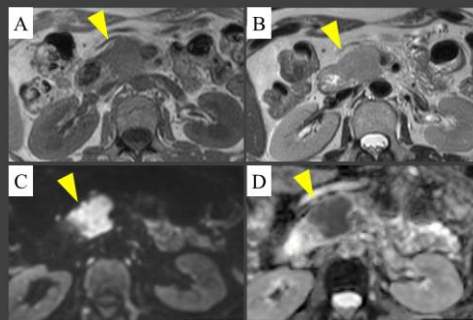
A) T1 weighted image, B) T2 weighted image, C) Diffusion-weighted image (b=1000), D) Apparent diffusion coefficient map. Magnetic resonance imaging showed the pancreatic swelling was improving (arrowheads).
